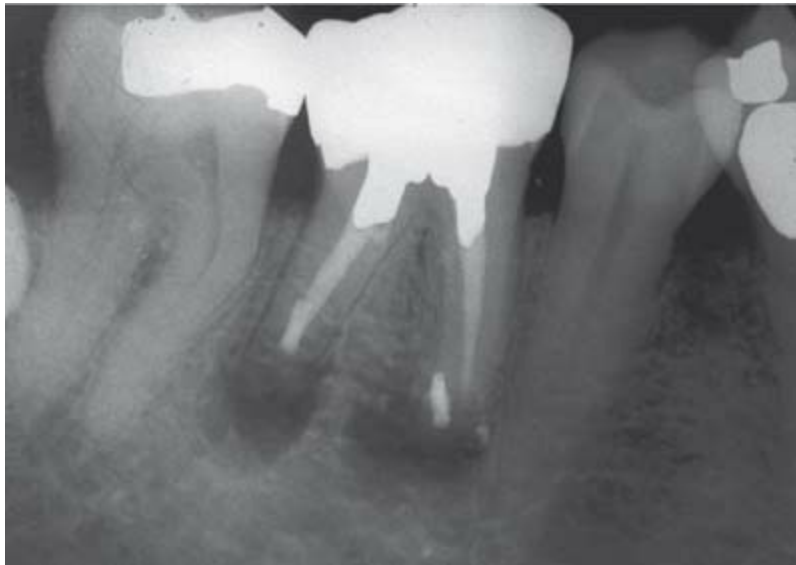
Error in root-end cavity preparation: ultrasonic preparation did not follow the long axis of the mesial root and therefore did not allow for proper sealing of this root. Healing is unlikely.
